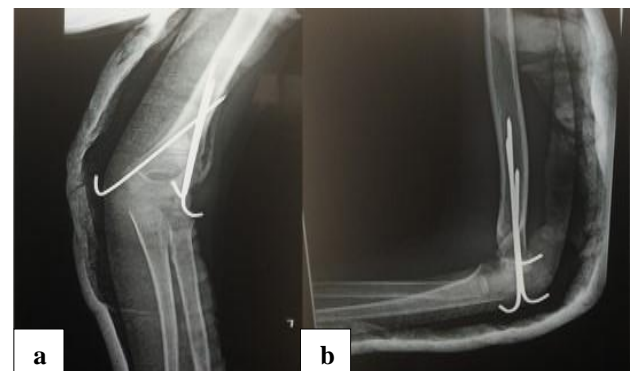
(a and b): Post-operative X-ray.
